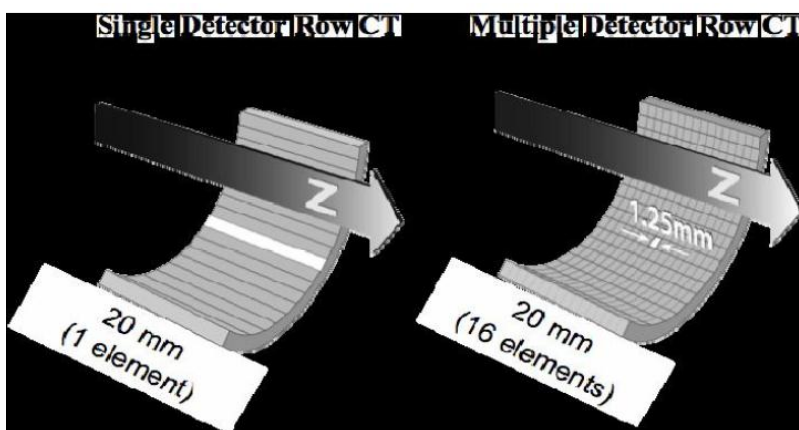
single CT detector versus Multi slice CT detector. From (ICRP 32/219,2006).
